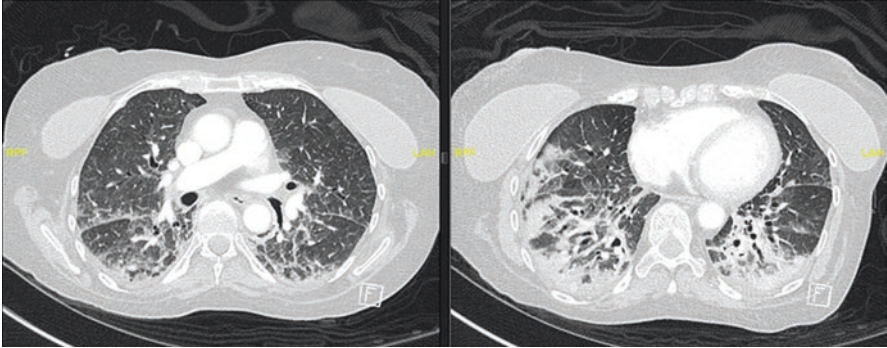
Chest CT of a patient with Legionella pneumonia
